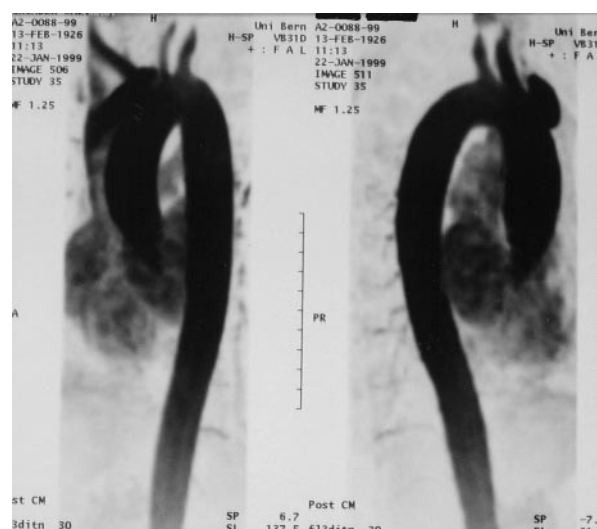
Magnetic resonance imaging of the patient shown in Fig 2 6 months after transaortic thrombectomy, showing no recurrence of the mural aortic thrombus.
